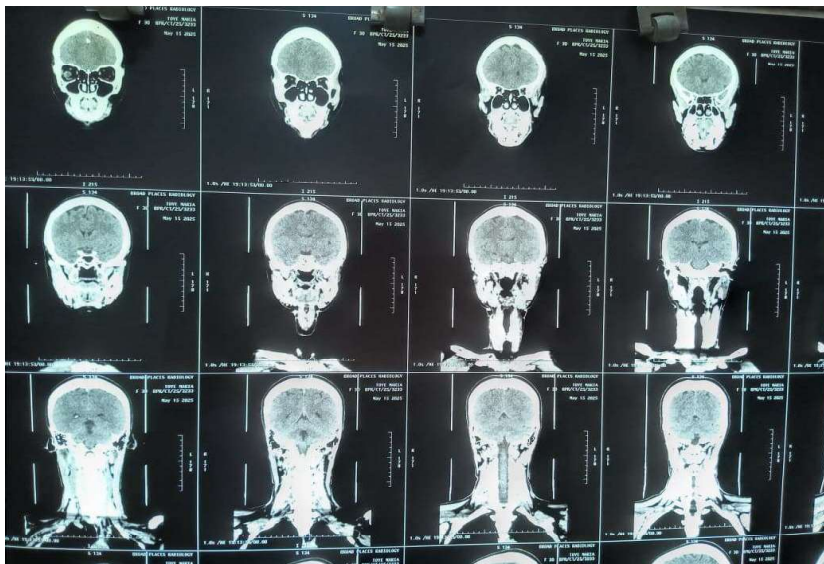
Sagittal view of Craniofacial CT scan
